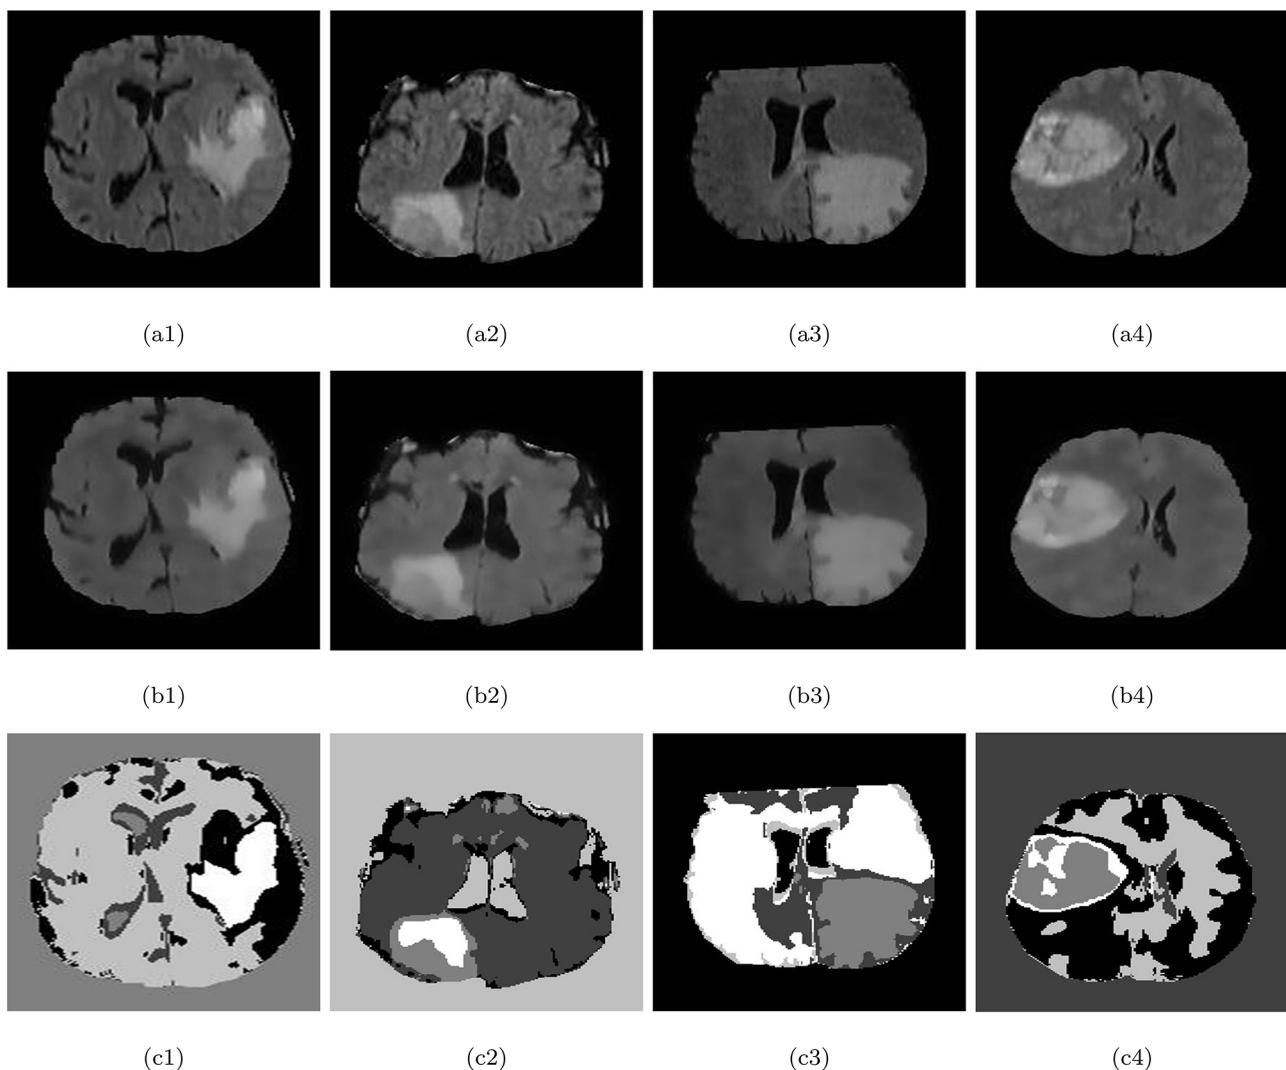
The image (a1–a4) shows the original FLAIR MRI scans, image (b1–b4) shows the preprocessed and de-noised enhanced image from bilateral filter, image (c1–c4) the output of textron maps images.
